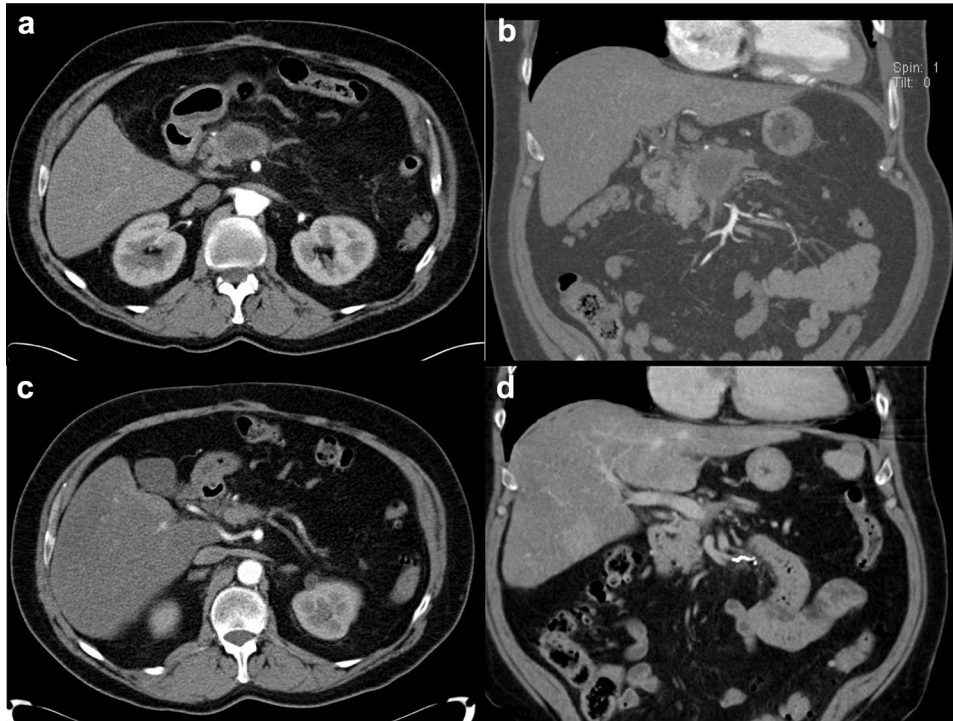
Coronal (a) and axial (b) arterial-phase computed tomography (CT) images 1 month after thrombin injection. The aneurysm sac has reduced in size to 4.4 cm and remains occluded. The 8-month follow-up CT scan shows virtually complete resolution of the aneurysm sac on coronal (c) and axial (d) views.
